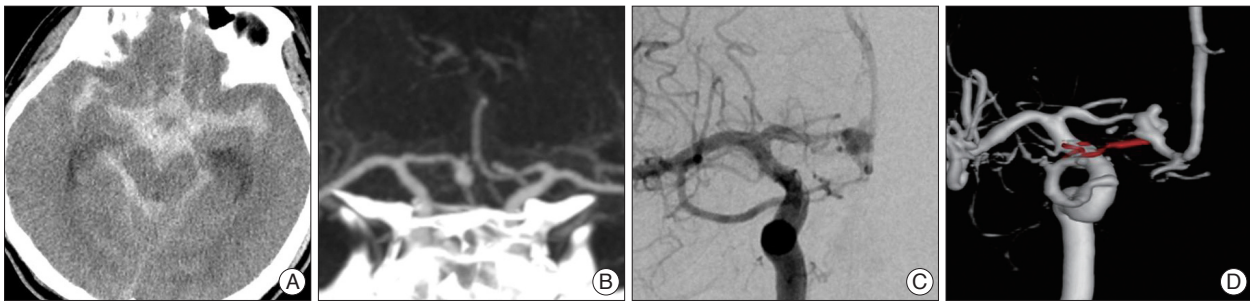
A and B : Preoperative CT demonstrating subarachnoid hemorrhage and aneurysm in right A1 segment of anterior cerebral artery. C and D : Postoperative angiogram showing a remnant aneurysm in right A1 segment of anterior cerebral artery.
